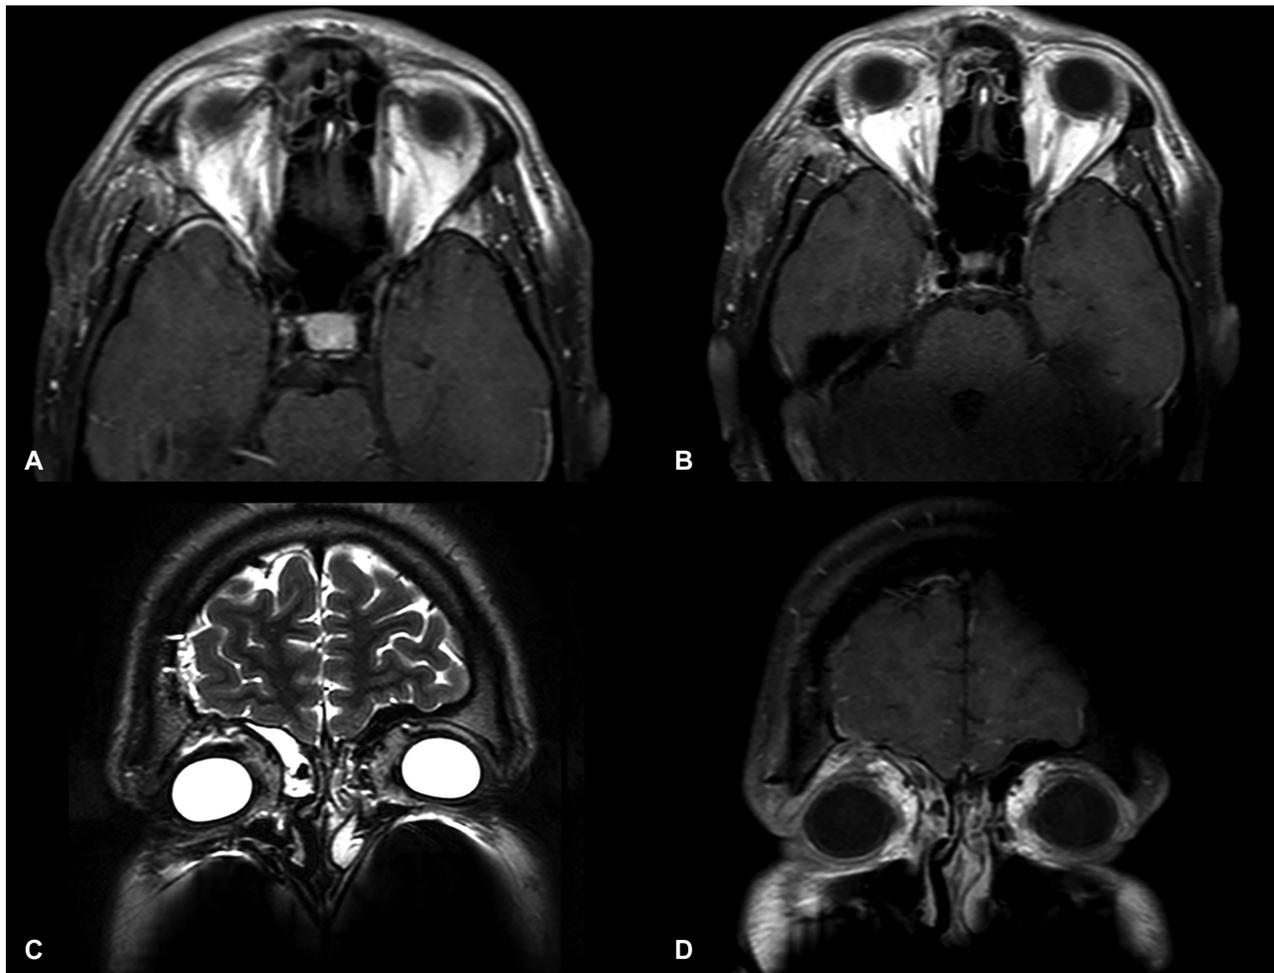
Postoperative axial and coronal magnetic resonance imaging showing a complete tumor resection with eye symmetry return and preservation of orbital structures.
